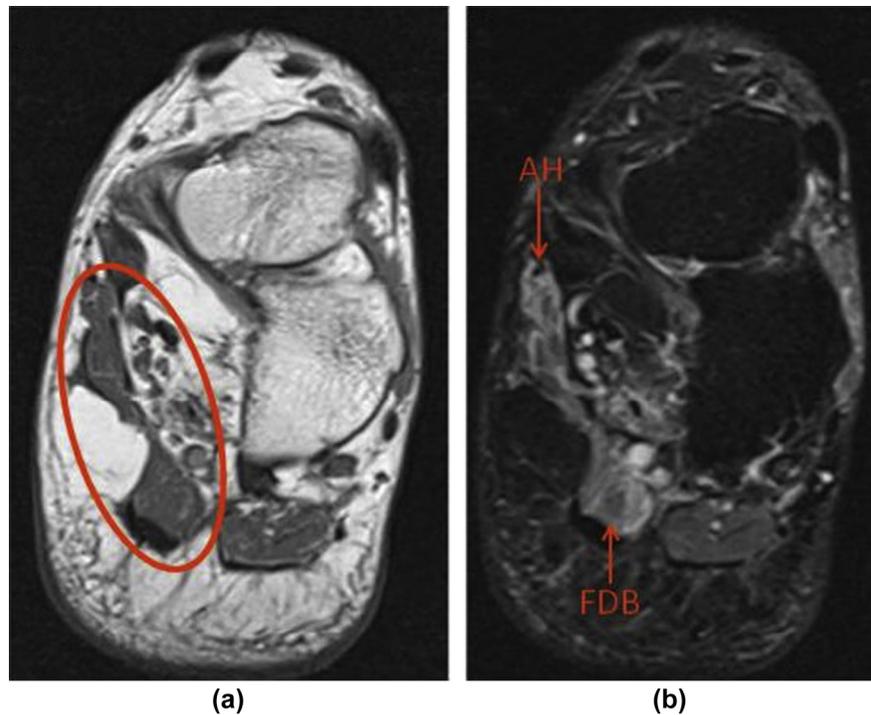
(a) T1-weighted and (b) short-tau inversion recovery (STIR) coronal MRI images show marked oedema and fatty atrophy of the abductor hallucis (AH) and flexor digitorum brevis (FDB) muscles. Although not specifically demonstrated here, tendon disease at the knot of Henry can indirectly cause entrapment of the medial plantar nerve. This may eventually lead to a denervation injury of the plantar foot muscles as shown above.
